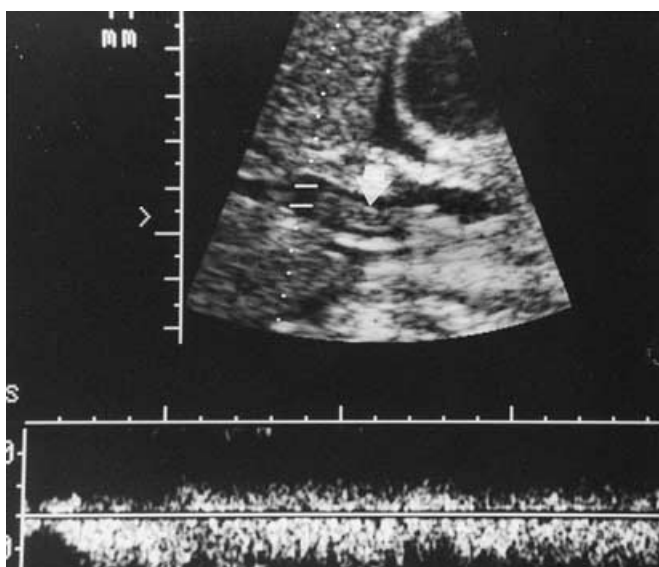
Thrombus in portal vein evident on pulsed Doppler ultrasonography. An echogenic thrombus (*arrow*) is within the lumen of the portal vein. The Doppler tracing indicates flow within the portal vein.
